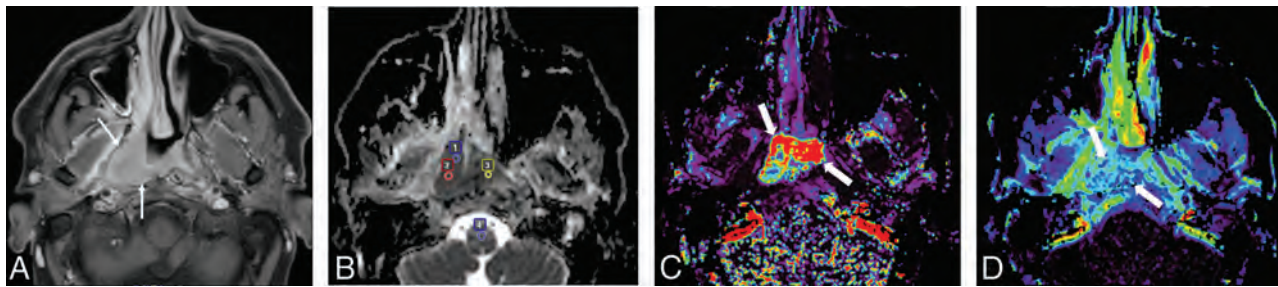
A case of nasopharyngeal cancer in a 37-year-old man. A mass lesion with enhancement (arrows) mainly on the right side of the nasopharynx is observed on the postcontrast fat-suppressed T1-weighted image (A). An ADC map (B) shows 3 ROIs (Nos. 1–3, small circles) within a low-signal lesion and 1 ROI (No. 4, small circle) for reference in the spinal cord, with an $nADC_{mean}$ of 0.86. DCE-MR imaging (C, Kep map; D, Ve map) shows the lesion (thick arrows) with a Kep of 3.14 minute^{-1} and a Ve of 0.36.
